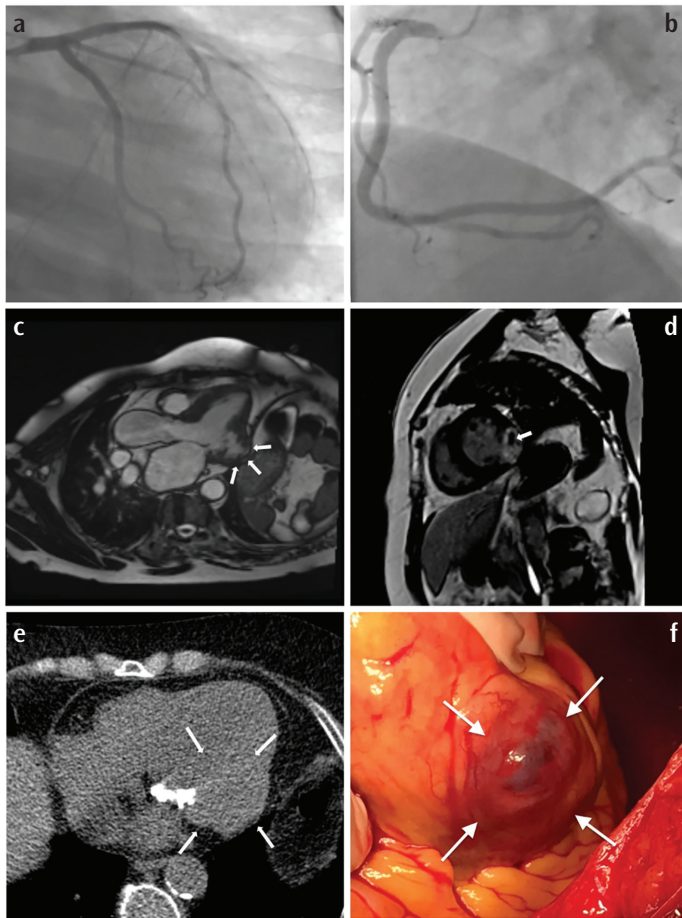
(a, b) Coronary angiography shows normal coronary arteries. (c) A 3-chamber image reveals a left ventricular aneurysm (arrows) measuring 41×23 mm. (d) A short-axis late gadolinium enhancement image shows a non-enhanced lesion (arrow) within the aneurysm sac, possibly thrombus or calcification. (e) Non-contrast CT shows no calcification within the aneurysm sac (white arrows), suggesting the lesion is thrombus (note: calcifications in the image are on the mitral valve). (f) Intraoperative image of the left ventricular basal pseudoaneurysm. CT, computed tomography.
